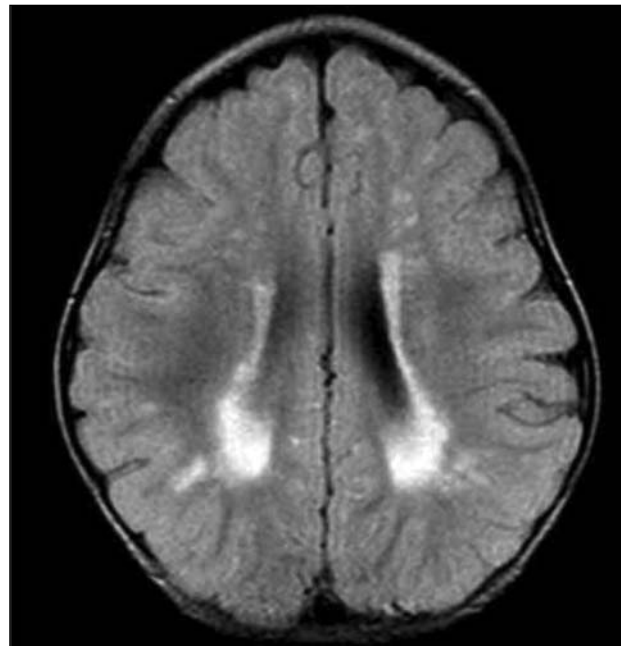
MRI FLAIR image showing diffuse and symmetric white matter hyperintensities.
